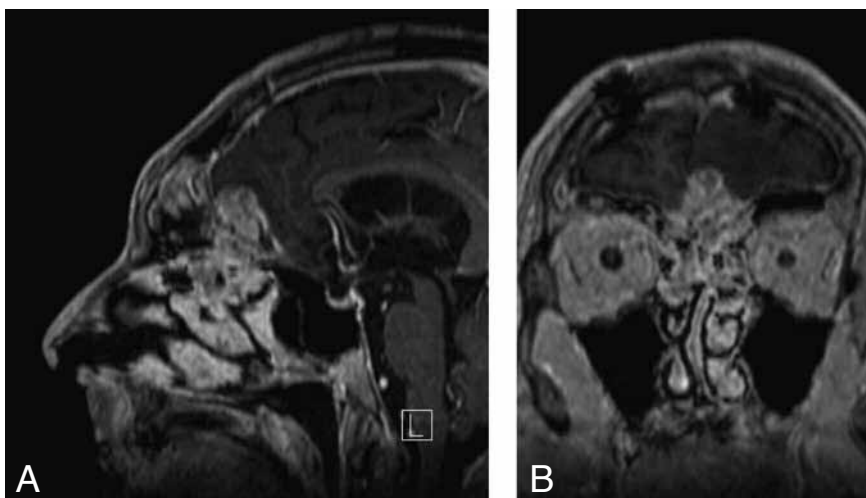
MR examination realized 1 year later, with sagittal (A) and coronal (B) T1-weighted slices, demonstrating a local recurrence of ENB.
